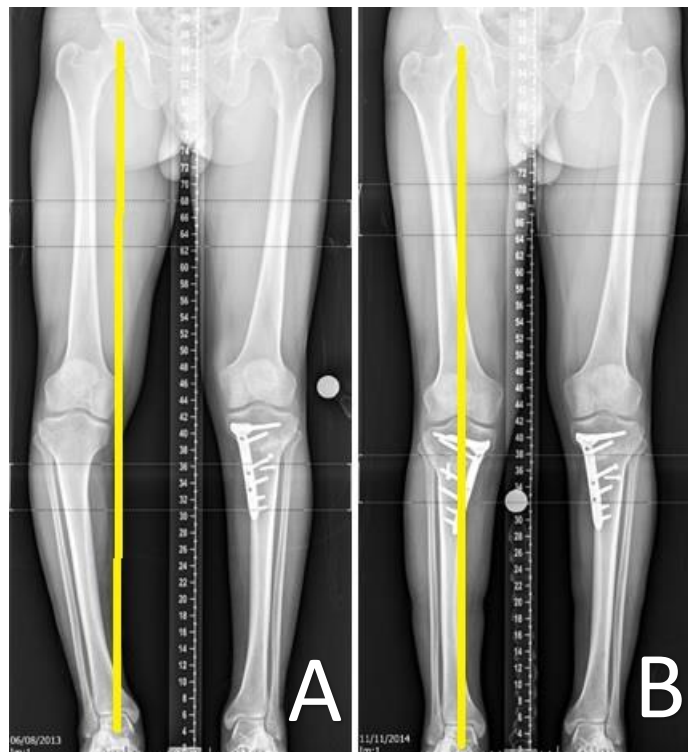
X-rays showing the (yellow) weightbearing line pre- (A) and post- (B) medial opening-wedge HTO
